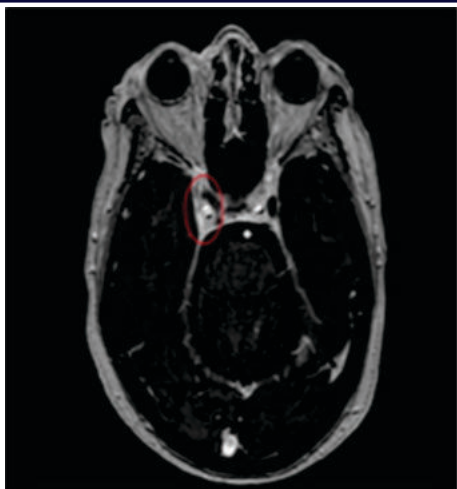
MRI Brain Showing Left Sided Cavernous Sinus Thrombosis
